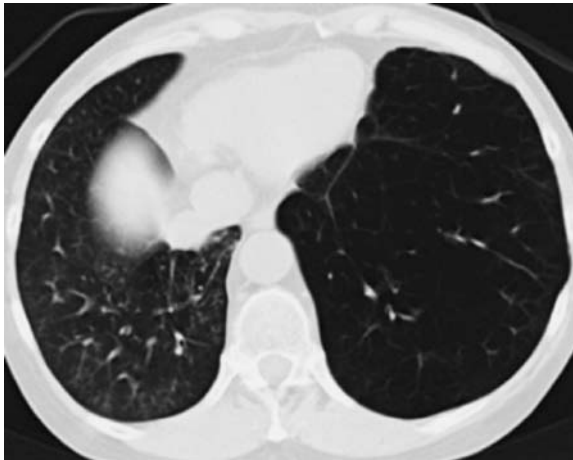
Transverse CT section in a single right-lung transplant recipient. Native emphysematous lung (*left*) is overinflated, while the transplanted lung shows normal density
